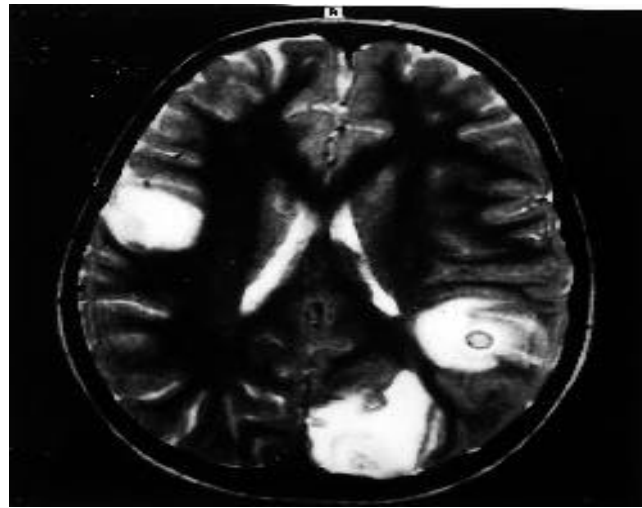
MRI T2 image showing three cysticerci lesions with extensive surrounding edema.
